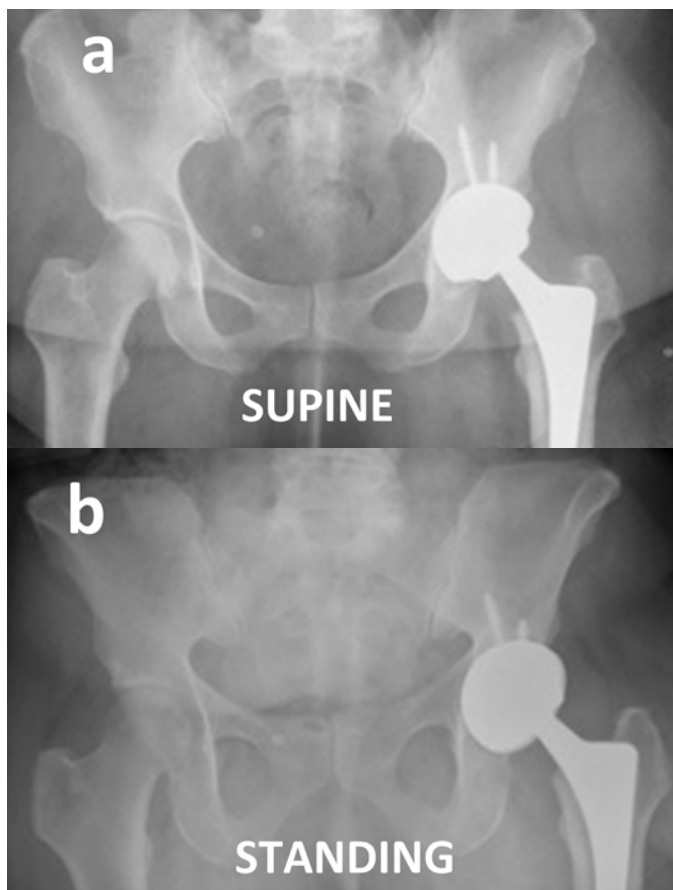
Supine and functional radiographs of a patient experiencing recurrent anterior dislocations.
